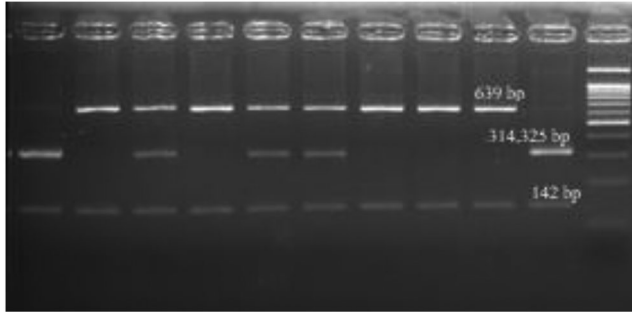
Gel image of the PDYN rs1997794 polymorphism. (1st well CC, 2nd well TT, 3rd well CT, 11th well 100 bp DNA marker).
